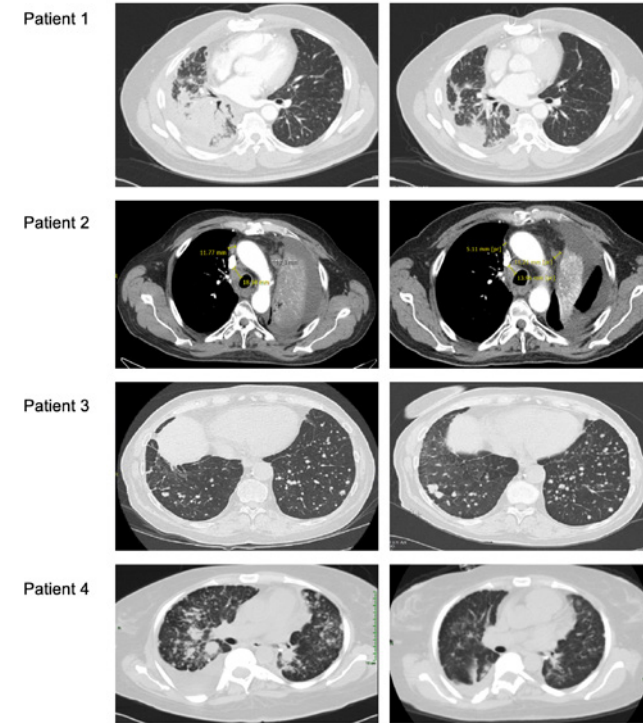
CT scans of the thorax performed prior (baseline) and after treatment onset (response).
